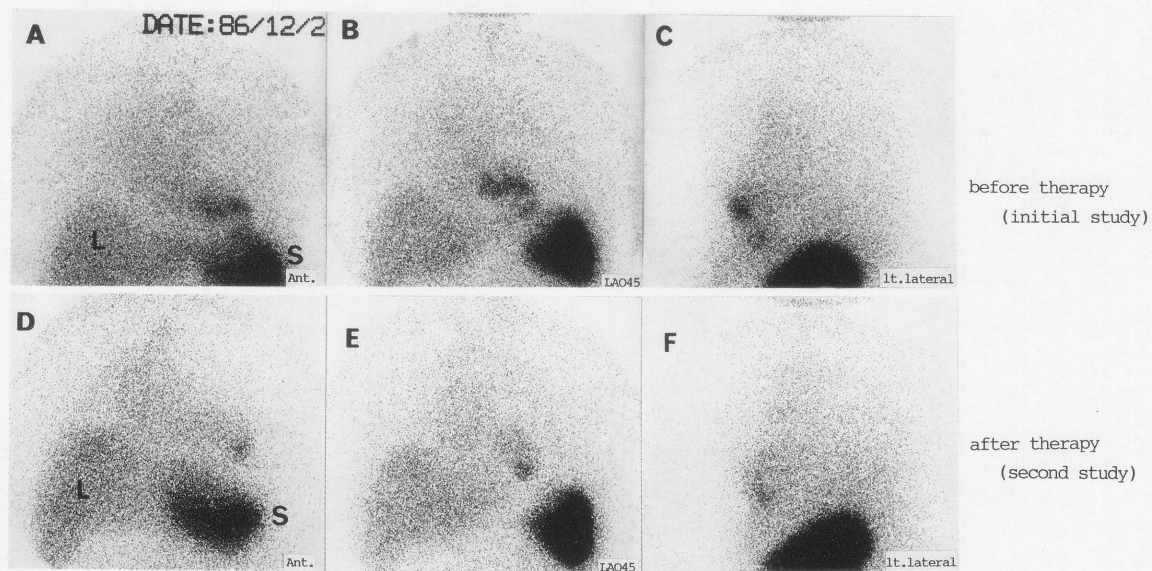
Indium-111-labeled platelet scintigram obtained 48 hours after injection of the platelet suspension. After anticoagulant therapy (Ticlopidine; 300 mg/day), indium-111 activity in a large anteroapical LVA was significantly reduced (panels: D, E and F) compared with that of scintiphotos (frames A, B and C) before the therapy. L: Liver, S: Spleen (K.T. 57-year-old male)
